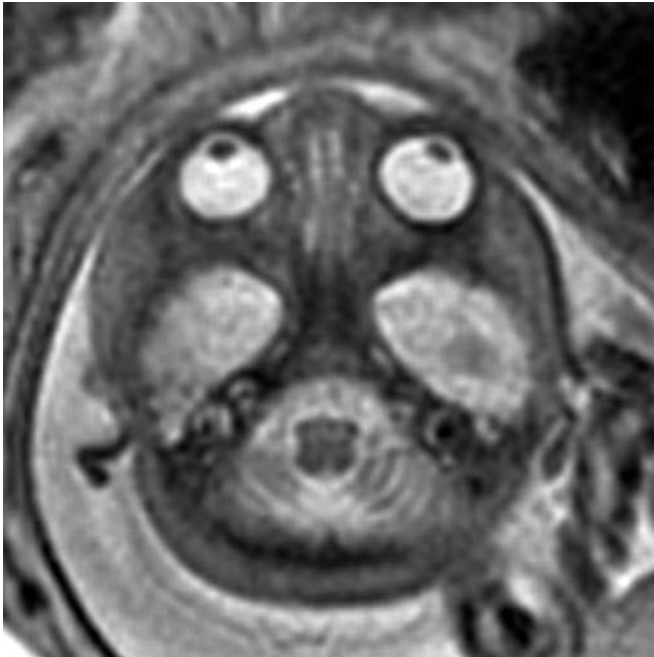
Normal orbits on fetal MRI. The entire lens has a low signal compared with the high signal of the vitreous. (From Robinson AJ, Blaser S, Toi A, et al. *Magnetic resonance imaging of the fetal eyes—morphologic and biometric assessment for abnormal development with ultrasonographic and clinicopathologic correlation*. *Pediatr Radiol*. 2008;38:971–981.)
